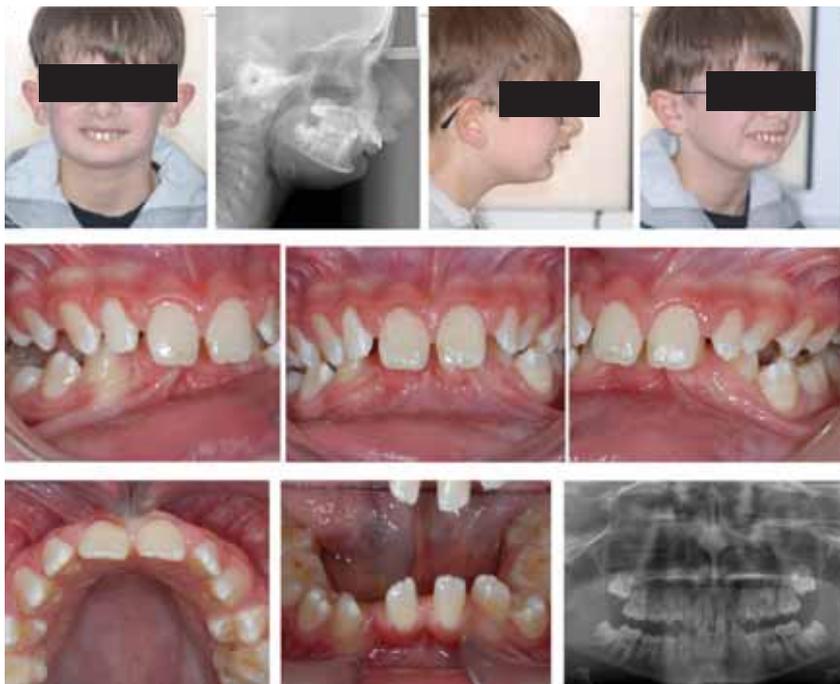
Standard photographic and radiographic records as a basic record for every patient.
